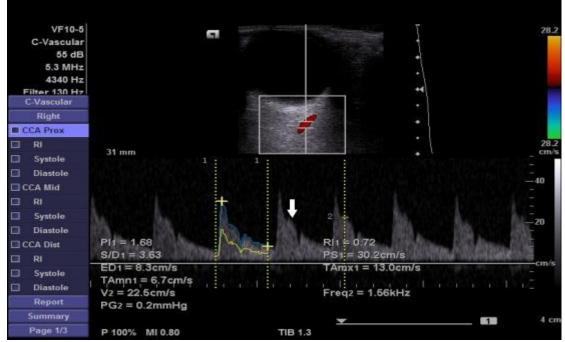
Right ophthalmic artery Doppler study at 11 weeks of gestation of case (2). The patient developed mild preeclampsia on follow up
